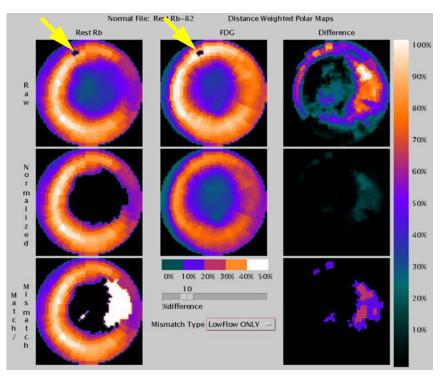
The pixel that is used for normalizing the FDG study relative to the perfusion study is set to black on this display, as indicated by the yellow arrows.
